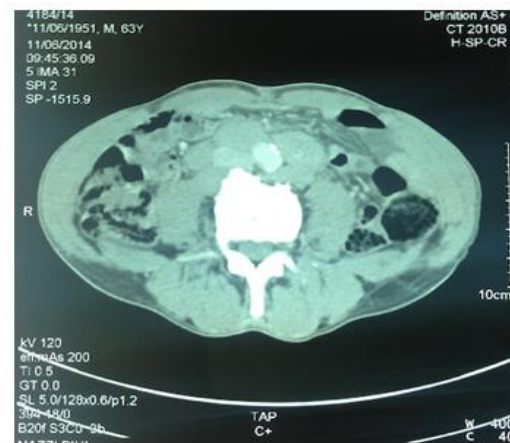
Image showing a CT lymphadenopathy magna inter aorto - cellar.
